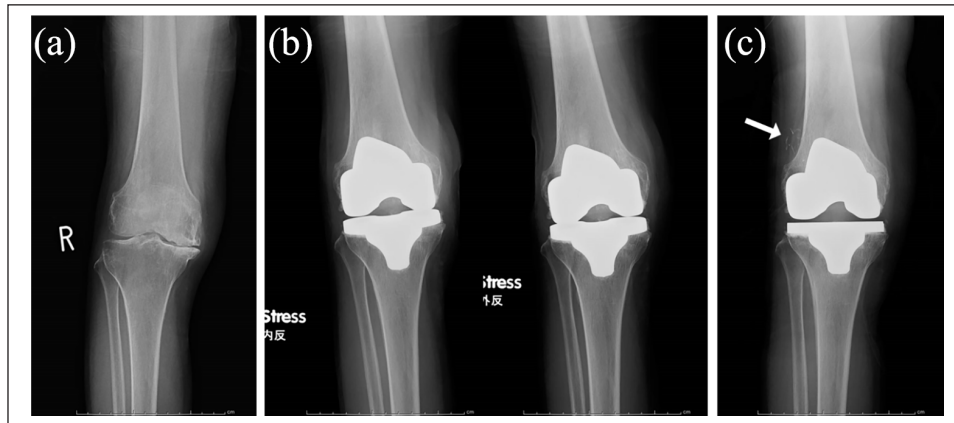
(a) Radiograph shows preoperative anteroposterior (AP) view of the right knee. (b) Radiographs at 6 months after surgery show no findings of instability, loosening, or osteolysis (right: varus stress AP view, left: valgus stress AP view). (c) Radiograph at 8 months after embolization shows Lipiodol in the superior lateral aspect (white arrow).
